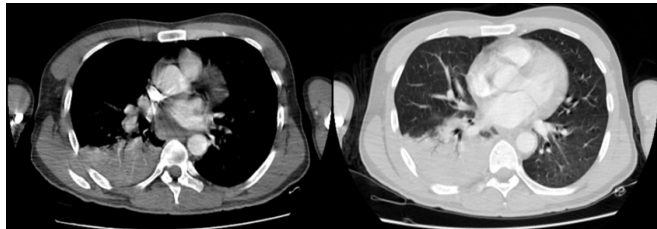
Computed tomography image shows consolidations including air bronchogram in the sections of mediastinum and parenchyma.
